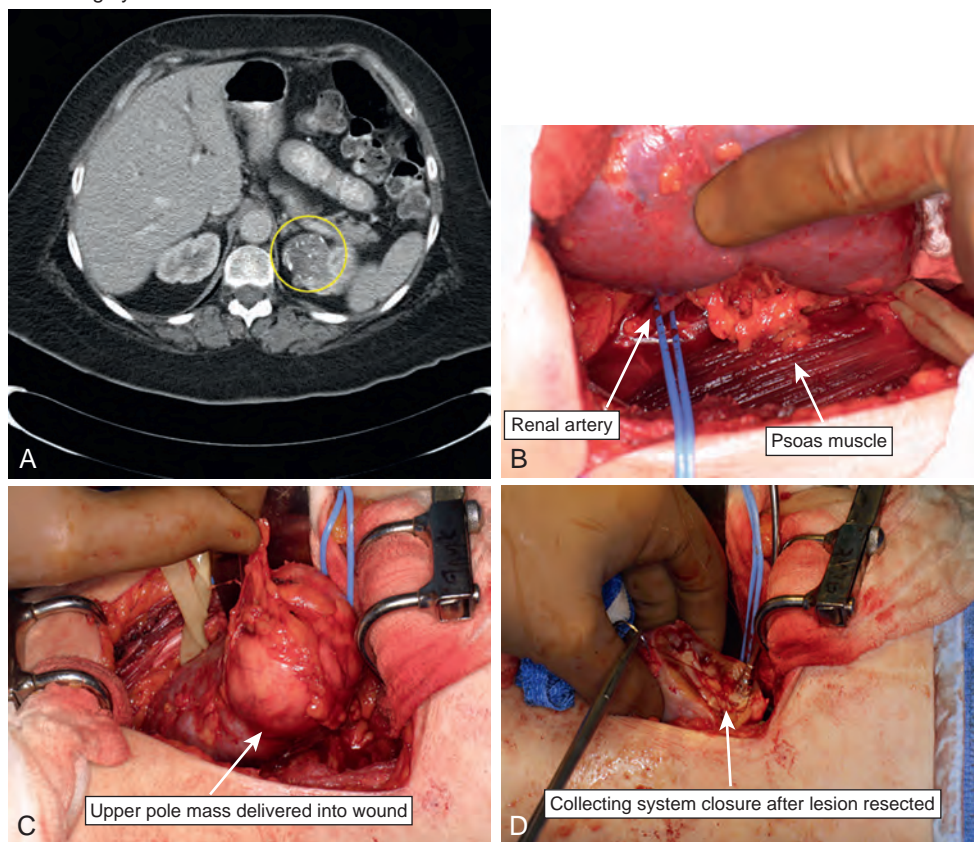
A, Renal tumor involving the collecting system demonstrated on computed tomography scan. B, Securing the renal artery. C, Identifying the upper pole mass. D, Repair of the collecting system after lesion resected.
